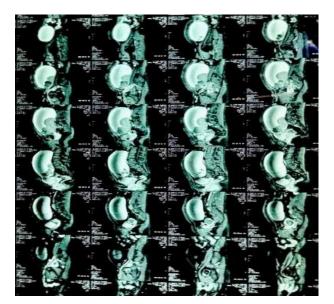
Sequential sagittal MRI sections showing a large multiloculated pelvic-abdominal mass with both cystic and solid components arising from the adnexal region. The lesion demonstrates mass effect with anterior displacement of the uterus and posterior compression of the rectum.
